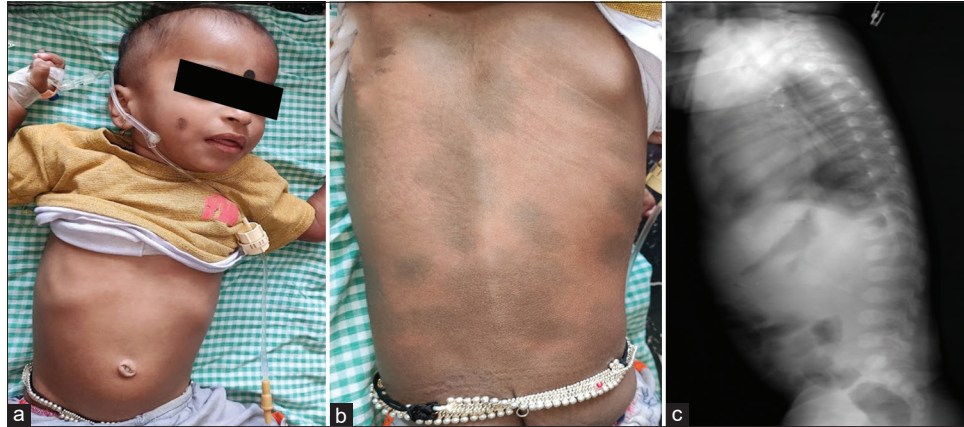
(a) Coarse facies, (b) Mongoloid macules in the lumbosacral region and (c) A lateral X-ray of the thoracolumbar spine with anterior beaking of vertebrae.
